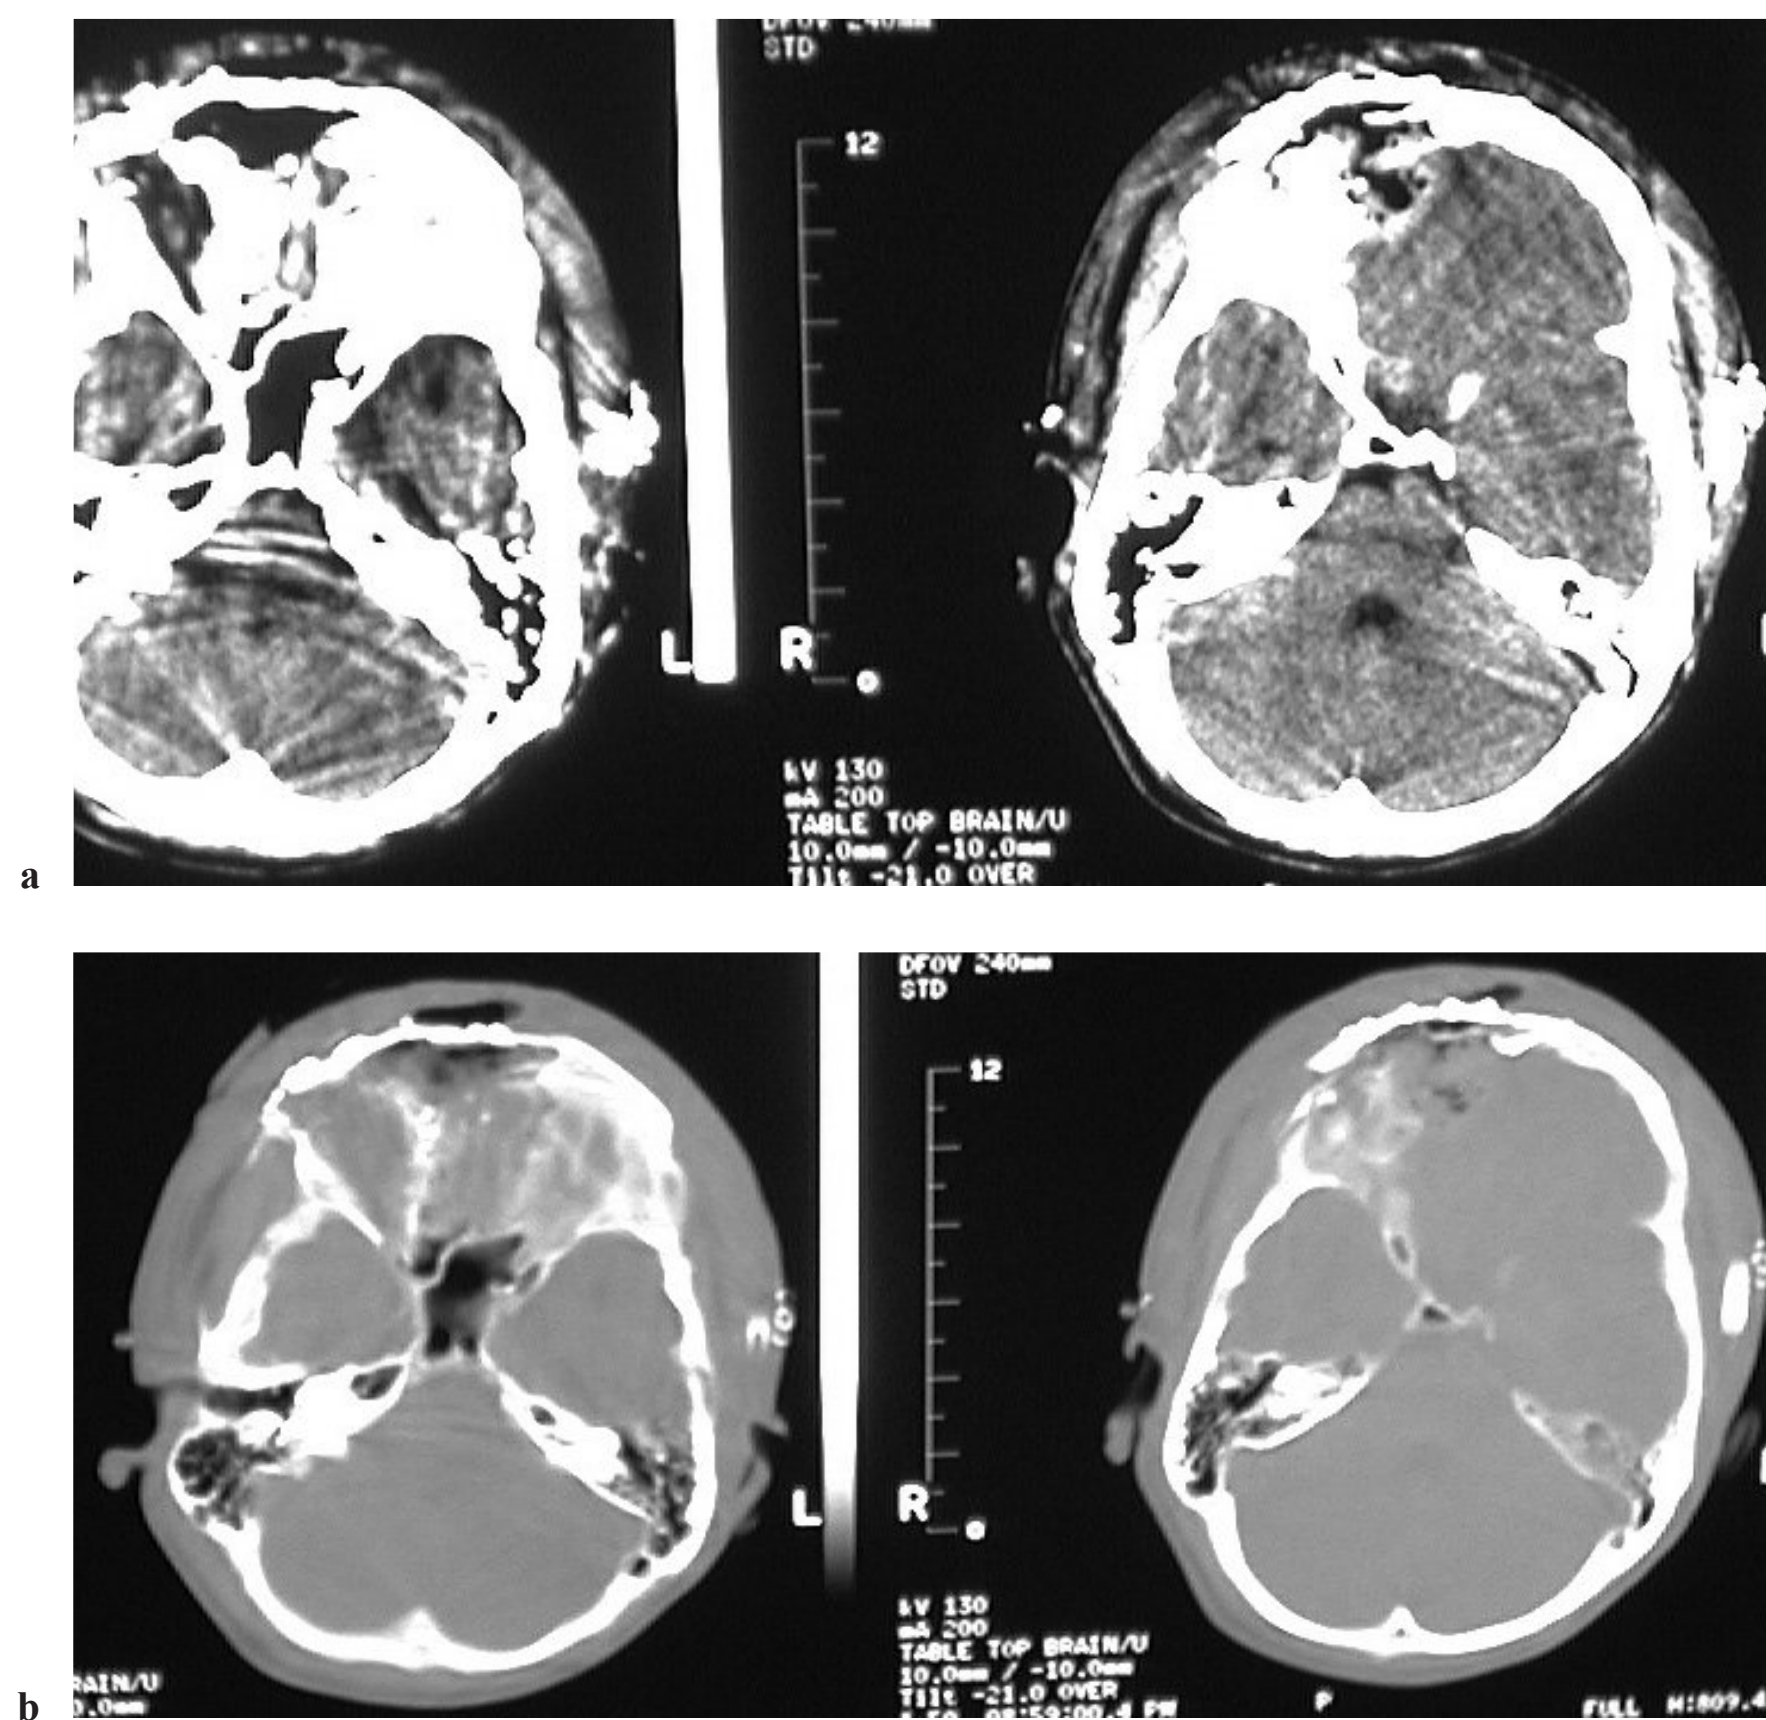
CT (a) brain and (b) bone windows obtained in the postoperative period.
